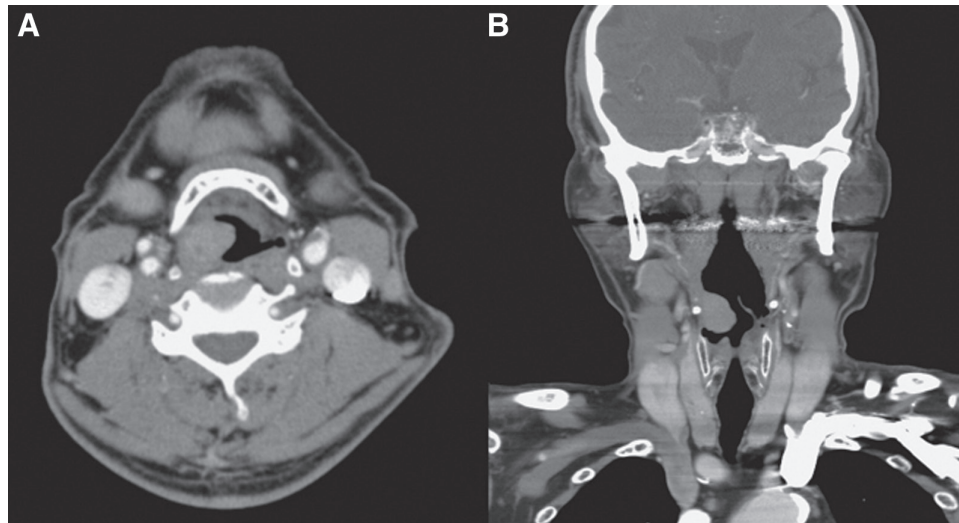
Computed tomography. A and B, Computed tomography of the larynx before transoral laser microsurgery. Axial (A) and coronal (B) postcontrast. A single, 15 mm × 18 mm × 10 mm, relatively well-defined and moderately-enhanced mass along the posterior surface of the right aryepiglottic fold.
